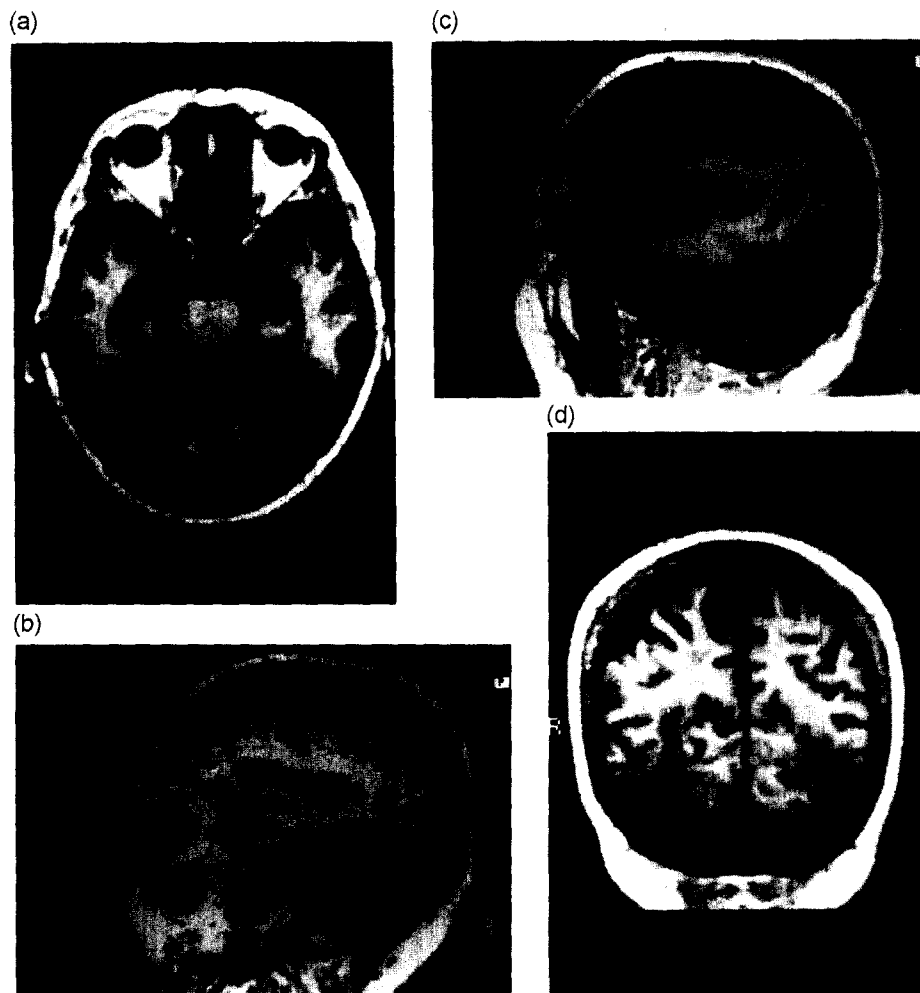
T1-weighted MRI scan showing symmetric lesions in Brodmann areas 18 and 19 and in the underlying white matter. On the left side, the lesion extends anteriorly to the inferior temporal gyrus (BA 37). Transversal (a), sagittal (b, c) and coronal sections (d) are shown.
